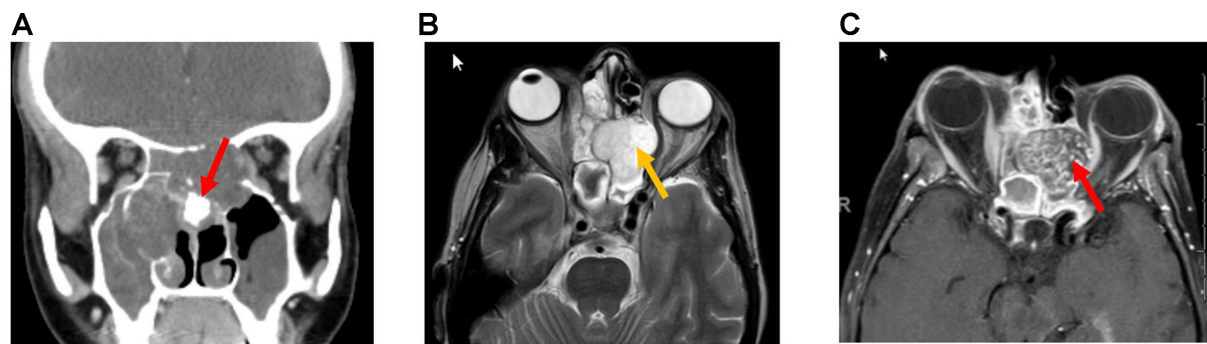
Sinonasal chondrosarcoma. (A) Coronal non-contrast CT demonstrates an ill-defined, low-attenuation mass expanding the nasal cavity and paranasal sinuses with osseous destruction and calcifications (arrow); (B) Axial T2-weighted MRI demonstrates the hyperintense cartilaginous matrix (yellow arrow); (C) Axial post-contrast T1-weighted MRI reveals the characteristic “rings and arcs” fibrovascular enhancement (red arrow). CT: Computed tomography; MRI: magnetic resonance imaging.
